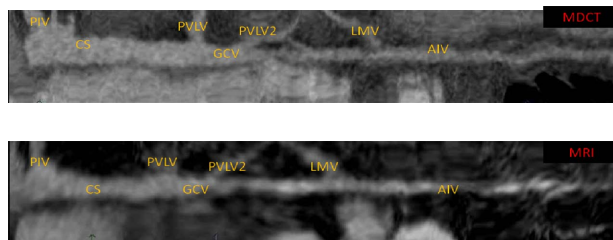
Stretched-out MPR coronary vein image by MDCT and MRI.
